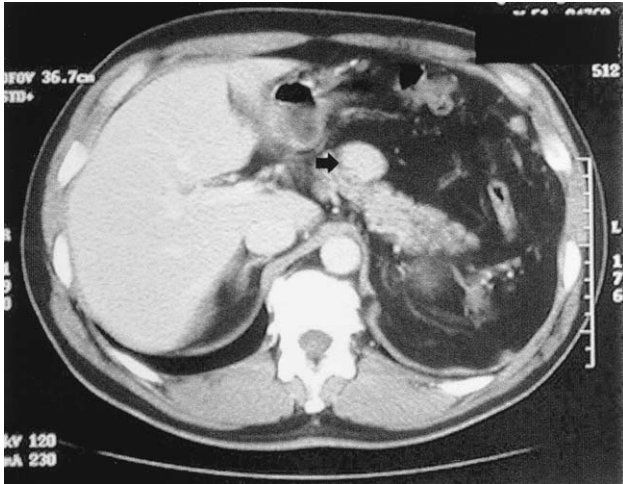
A hypervascular, solid mass is present in the body of the pancreas on CT scan (*arrow*).
